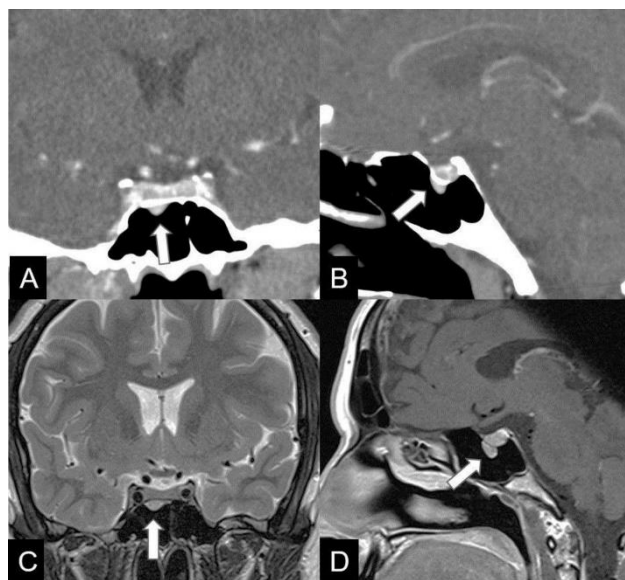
Coronal and sagittal CT images (A, B) demonstrate a well-defined solid mass (arrows) with homogeneous enhancement in the sphenoid sinus roof without defect of bony contour of sphenoid sinus. Coronal T2WI (C) and sagittal contrast-enhanced T1WI (D) MRI images show marked enhancement of the tumor in the sphenoid sinus roof (arrows).
